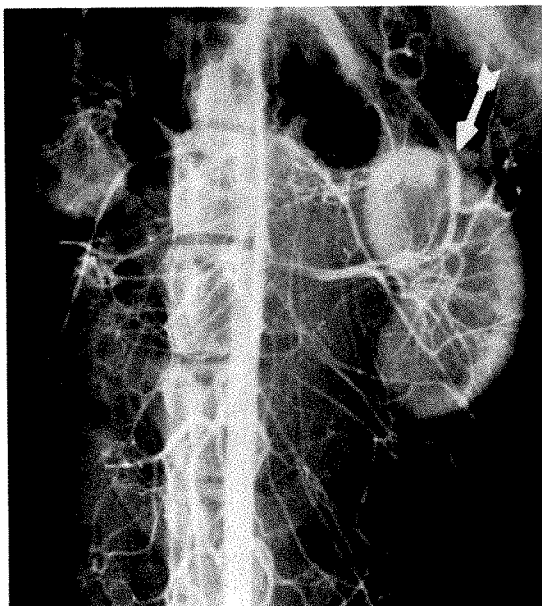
Case III. Roentgenogram made immediately following laceration $1\frac{1}{2}$ inches long. Note defect in cortex in early nephrogram phase. Cleft partly covered by a filled vessel.
